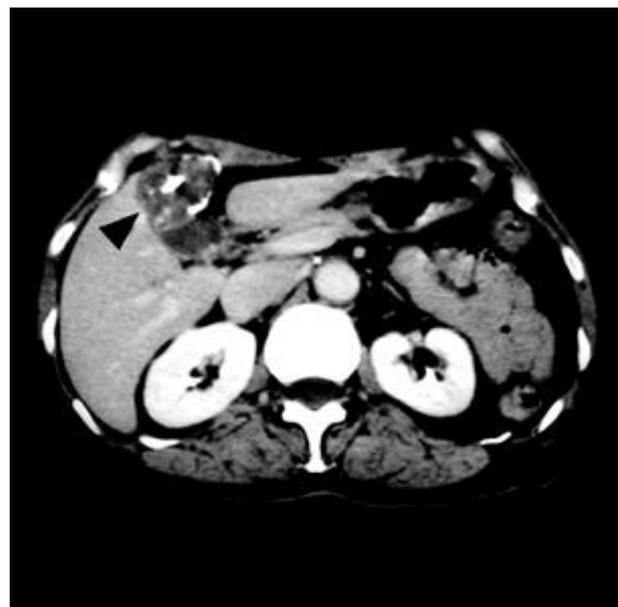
Contrast-enhanced abdominal CT scan shows a low attenuating mass with central and peripheral calcification (arrow head).
